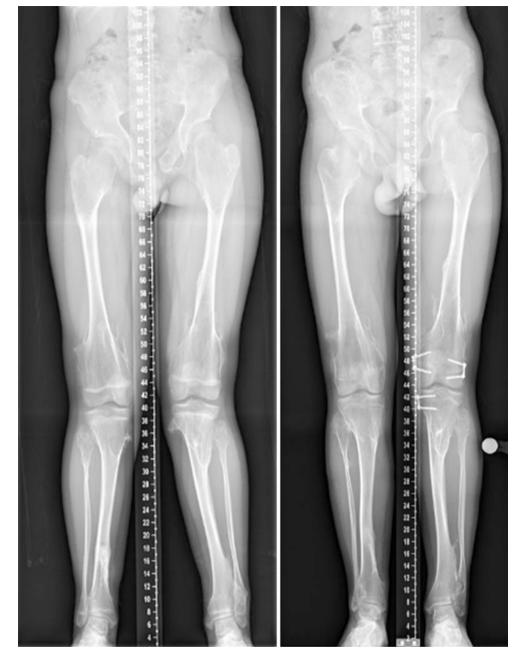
A plain radiograph of a patient with multiple bony exostosis
